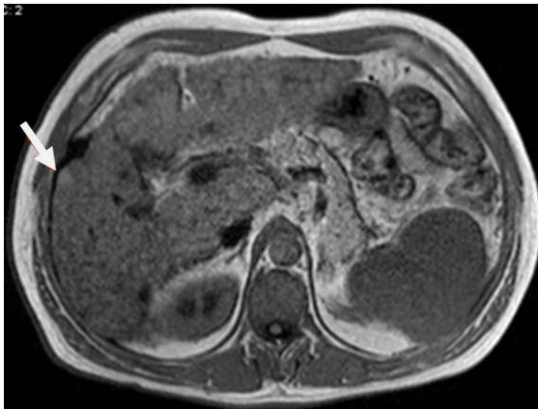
Dysplastic nodule – MRI axial T1: nodular lesion in the periphery of the right lobe, with slight hyperintensity compared to the adjacent parenchyma in a cirrhotic liver
